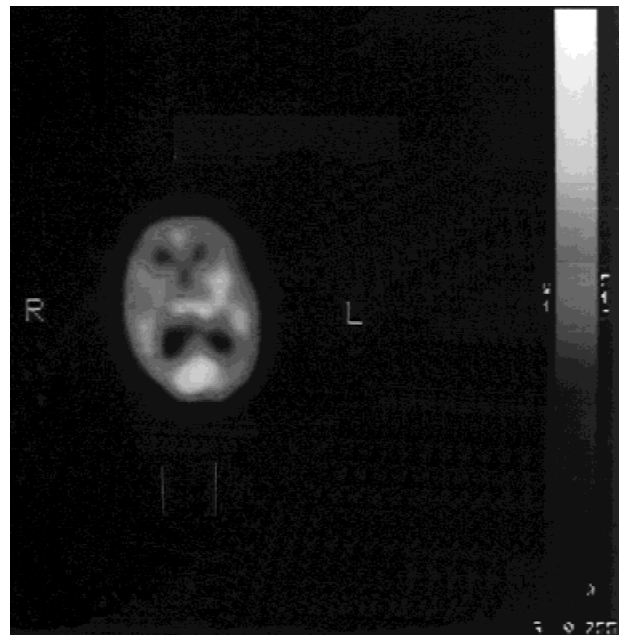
$^{99\text{m}}\text{Tc}$ ECD SPECT shows a global hypoperfusion of the right hemisphere.
